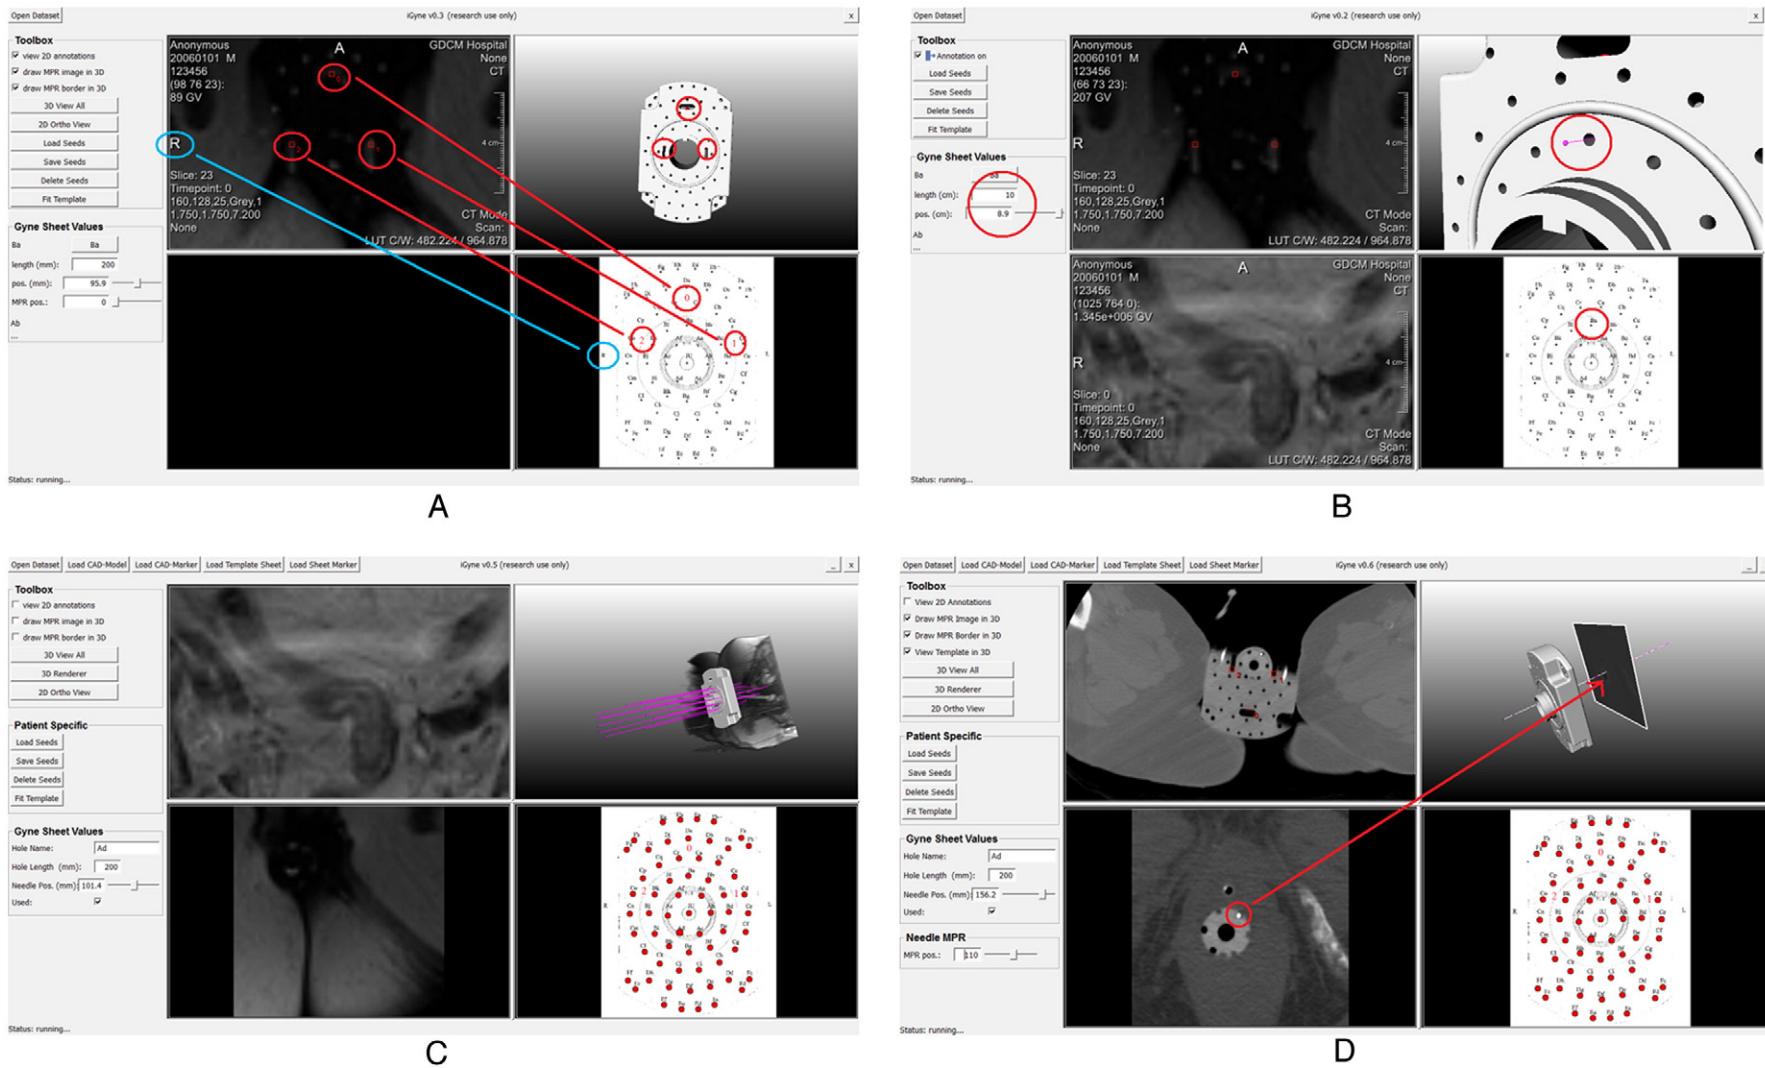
Principle for registering a template for gynecologic brachytherapy with the initial MRI image. (A) The three red circles indicate corresponding needle holes in the template and the MRI image. The registration is realized via a rigid transformation between these corresponding point sets. The blue circles are used to ensure that the left and right sides of the patient and the template are matched correctly. (B) Virtual fitted gynecologic brachytherapy template and selection of a specific interstitial needle (Ba, red circles in the screen shot). As shown on the left side of the prototype interface, individual needle insertion can be planned by defining parameters, such as the needle length and depth. (C) Virtual placement of several interstitial needles (purple) with different lengths and depths as shown in the settings in the menu in the left column. This allows the radiation oncologist to plan the placement of needles. (D) Needle (white line in the upper right image) that has been selected for visualization of MPRs along the needle path (lower left window). The MPR at the position of the arrow (tip of red arrow in the upper right image) is displayed in the lower left window as a 2D slice. In the MPR of the lower left window, the needle cross section (white) is surrounded by a red circle.
